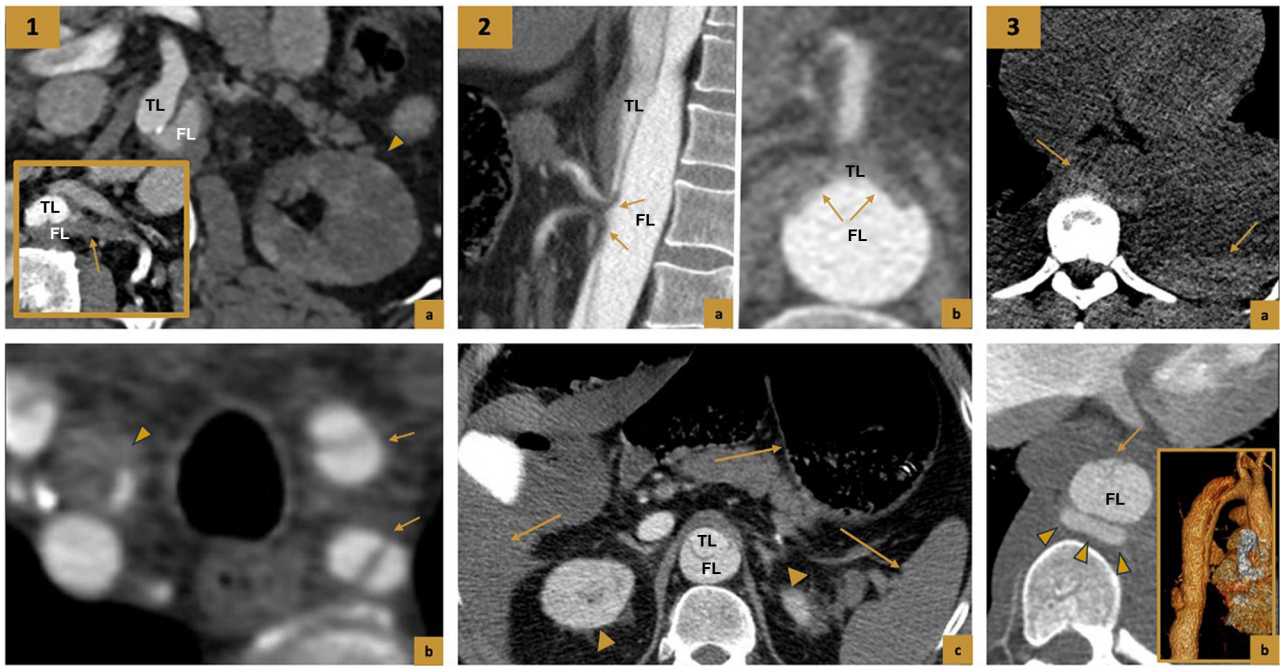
Complications of aortic dissection. 5.1 Renal hypoperfusion and right-sided stroke. (a) Contrast-enhanced CT scan in early arterial (inset) and portal phases, axial slices. Dissection *flap* extending into the left renal artery, with partial thrombosis of the lumen and severe hypoperfusion of the left kidney (arrowhead). (b) CT with contrast, axial slice. Extension of the dissection *flap* to the left carotid and subclavian arteries (arrows) and the right carotid artery, revealing a severely collapsed true lumen and thrombosis of the false lumen, which caused a right-sided stroke (not shown). 5.2 Contrast-enhanced CT scan in late arterial phases, sagittal and axial slices. Mesenteric ischaemia secondary to type B dissection due to severe pressurisation of the false lumen (a and b) which displaces the intimal *flap* anteriorly, occluding the origin of the coeliac trunk and superior mesenteric artery (arrows). (c) Contrast-enhanced CT in the portal phase, axial slice. Severe generalised hypoperfusion of the liver, spleen, and small intestine and colon loops (arrows) with respect to both kidneys (arrowheads), which were spared, consistent with massive mesenteric ischaemia, which was later confirmed in the operating theatre. 5.3 Rupture of the false lumen. Non-contrast CT, axial slice (a) Periaortic haematoma in the posterior region and moderate left haemothorax (arrows). (b). Late arterial phase contrast-enhanced CT, axial slice showing a severely collapsed true lumen in the anterior region with significant distension of the false lumen and a contrast-enhanced image (volumetric reconstruction) at its posterior margin (arrowheads) consistent with rupture of the false lumen.
